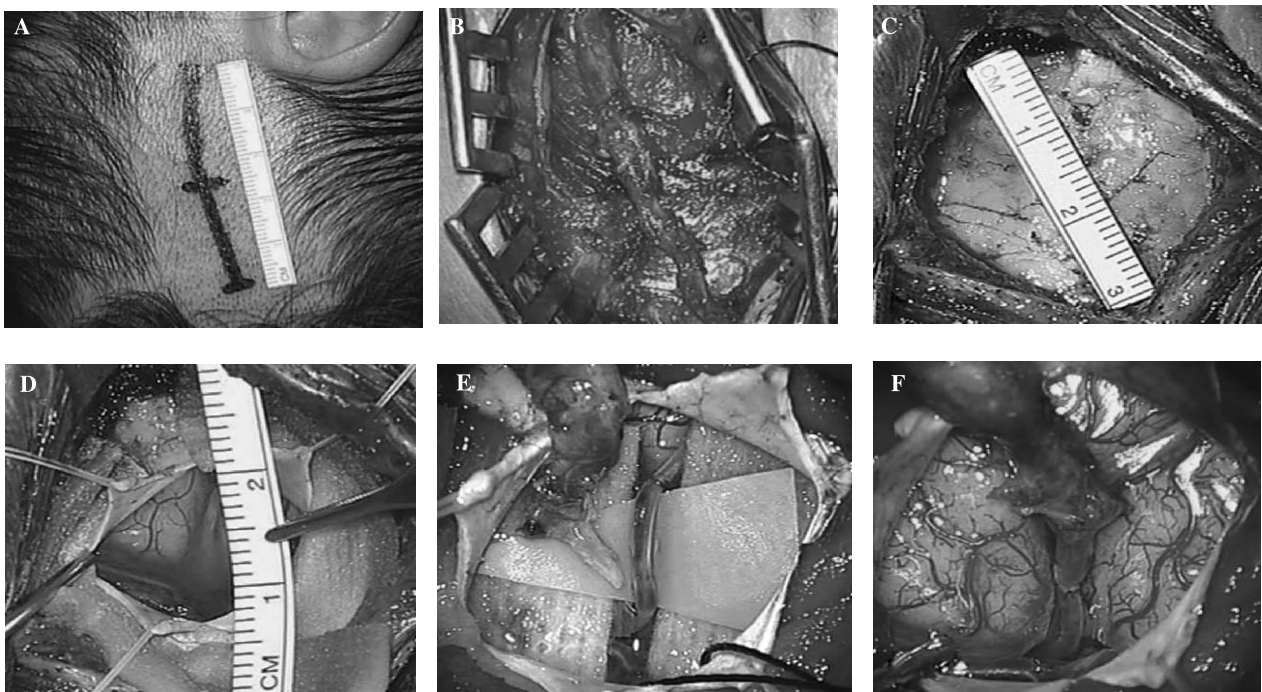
(A) 5 cm linear skin incision on the parietal or frontal branch of STA, the center of which was the point measured on preoperative 3D CTA. (B) Dissection of parietal branch of STA. (C) 3 cm of small craniotomy. (D) Small opening of the dura in the center of craniotomy. (E) The recipient artery could be identified on the center of the craniotomy. (F) End-to-side anastomosis was completed with interrupted sutures
